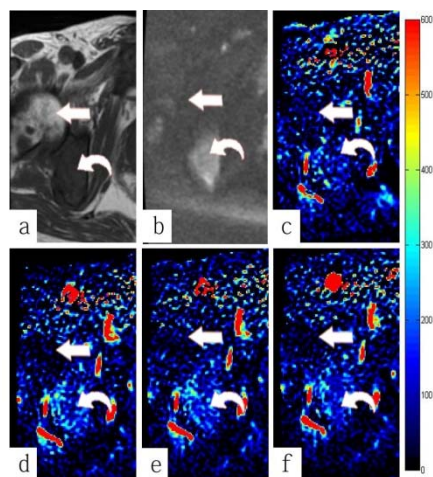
(a-b) A 75-year-old man with bone metastasis from prostate cancer. The bone metastasis (right ischium) (curve arrow) showed lower signal in T1 and higher signal in DWI than normal bone (femur head) (straight arrow); (c-f) The corresponding BF mappings with different TI showed higher perfusion characteristics.
